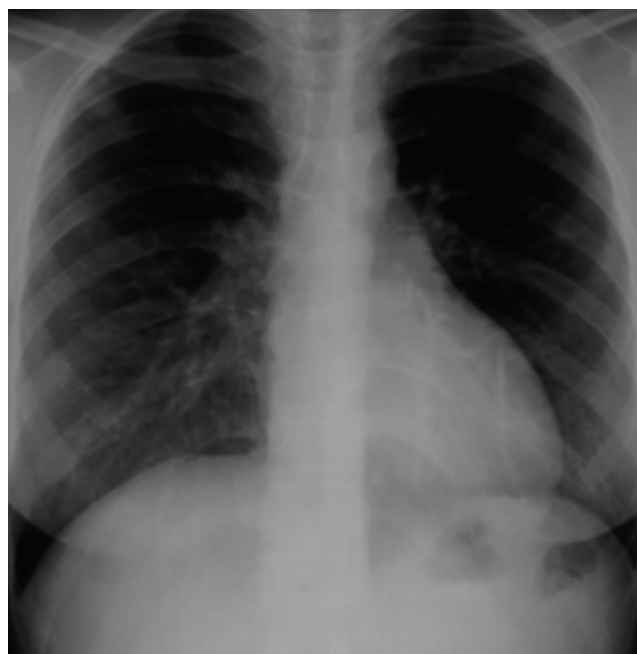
Pulmonary tuberculosis in a 44-year-old man who received renal transplantation a year ago. Chest radiograph shows air-space consolidation in both upper and right lower lungs.
